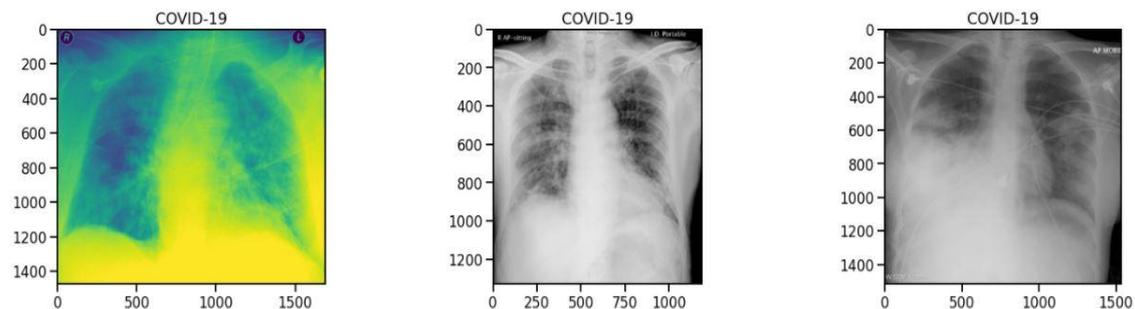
Chest X-ray images of COVID-19 infected patients
